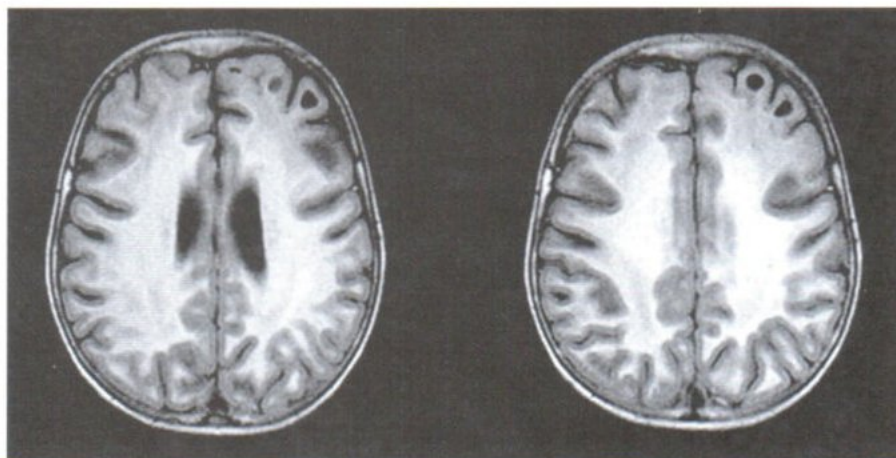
Axial FLAIR images show diffuse abnormal hyperintensity of the cerebral white matter with several left frontal subcortical cysts.
